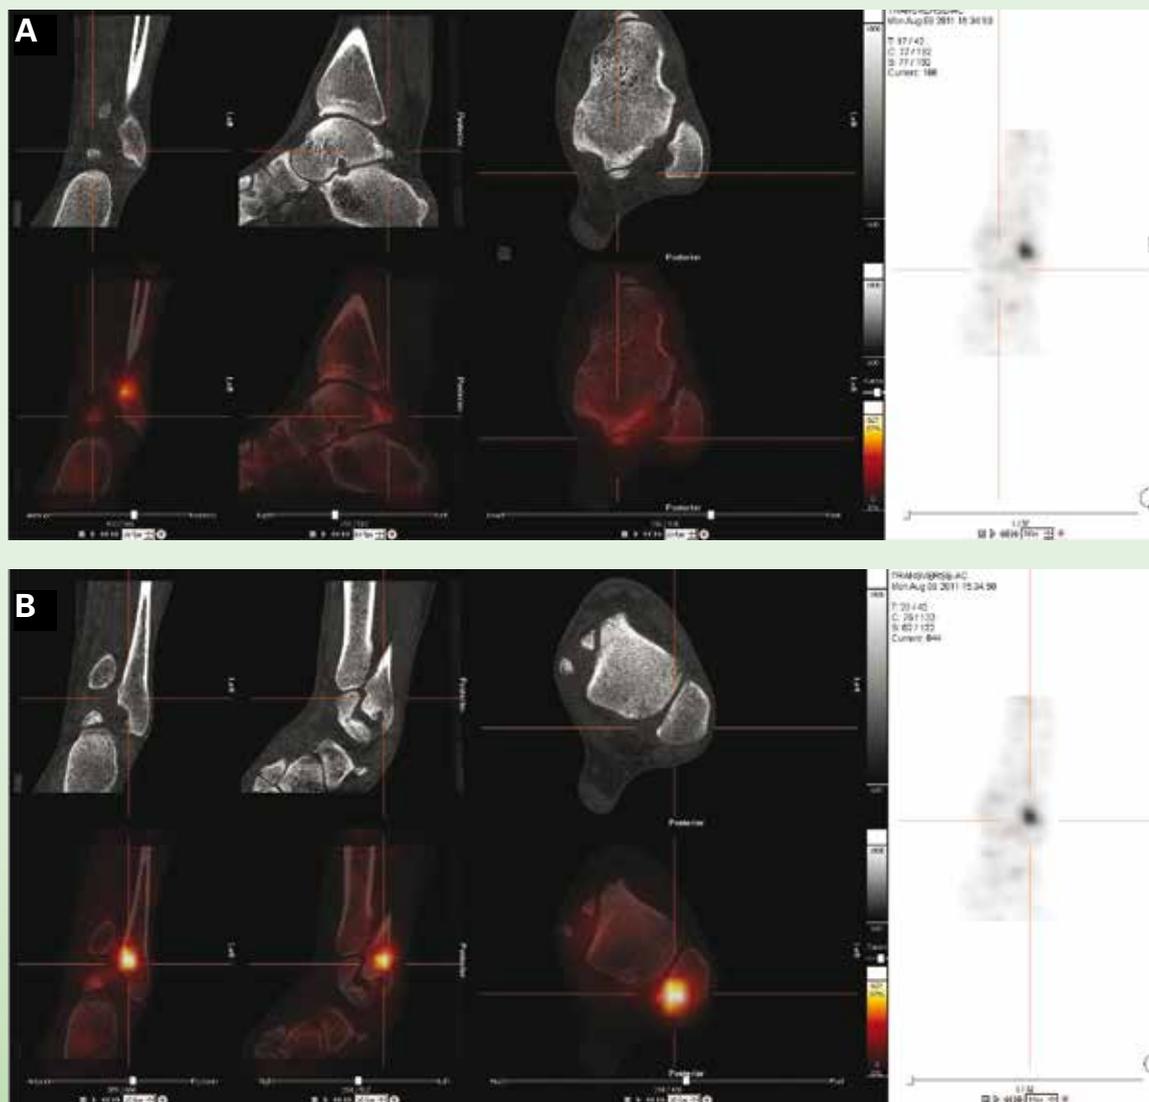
SPECT/CT of patient nr 2 showing increased uptake at the distal fibula posteriorly (B), and barely increased uptake at the os trigonum (A).
